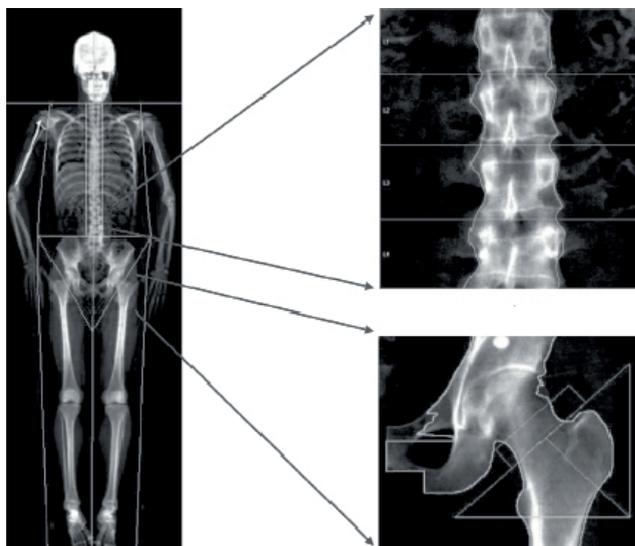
Dual-energy X-ray absorptiometry (DXA) of the total body (left panel), at the lumbar spine (upper right panel) and femoral neck (lower right panel) to measure bone mineral density.
